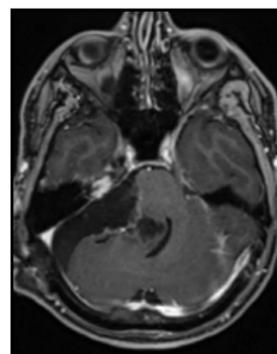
Post-operative MRI demonstrating small residual mass in internal auditory canal.
